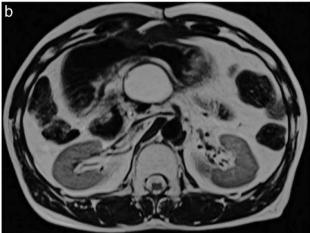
MRI showed a cystic mass in the surgical margin 9 months postoperatively. The capsule of the cystic mass was enhanced and its contents were seen as low intensity on the T1-weighted image (a) and high intensity on the T2-weighted image (b and c).
